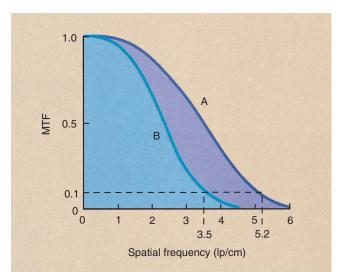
Modulation transfer function (MTF) curves for two representative computed tomography imaging systems. Imaging system A has higher spatial resolution than imaging system B.
